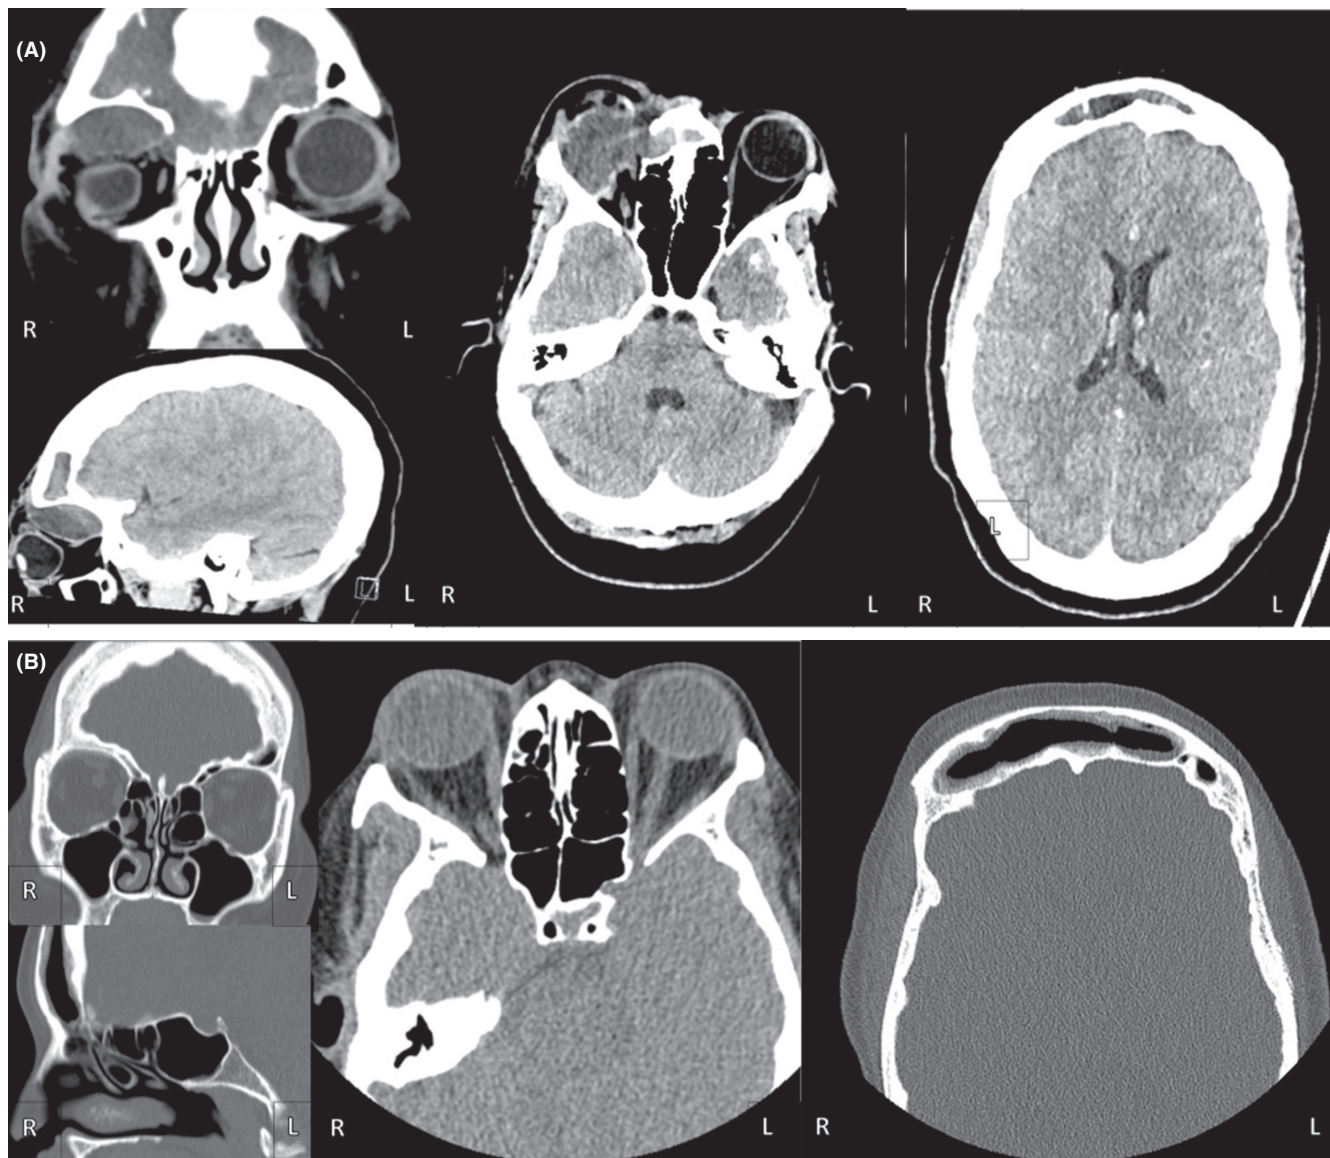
CT Imaging. (A) Unenhanced CT Orbit with contrast prior to surgery. Sagittal, coronal, and axial views show an expanded and markedly enlarged frontal sinus with mucosal thickening (arrow) and swelling of the soft tissues overlying the orbit and forehead. There is a destruction of the right lamina papyracea anteriorly. The frontal sinus and anterior ethmoid air cells were completely opacified and a low-density collection is seen eroding through the lamina papyracea into the superior aspect of the orbit causing superio-posterior globe indentation and proptosis. There is an extraconal low-attenuation collection displacing the extraocular muscles and retrobulbar fat. There is no intracranial extension of the mucocele. (B) CT unenhanced orbit at 3 months follow-up. The mucocele has been drained and there is no sign of re-stenosis. Proptosis has largely resolved. Minimal thickening of soft tissues anteriorly over the surgical defect.
